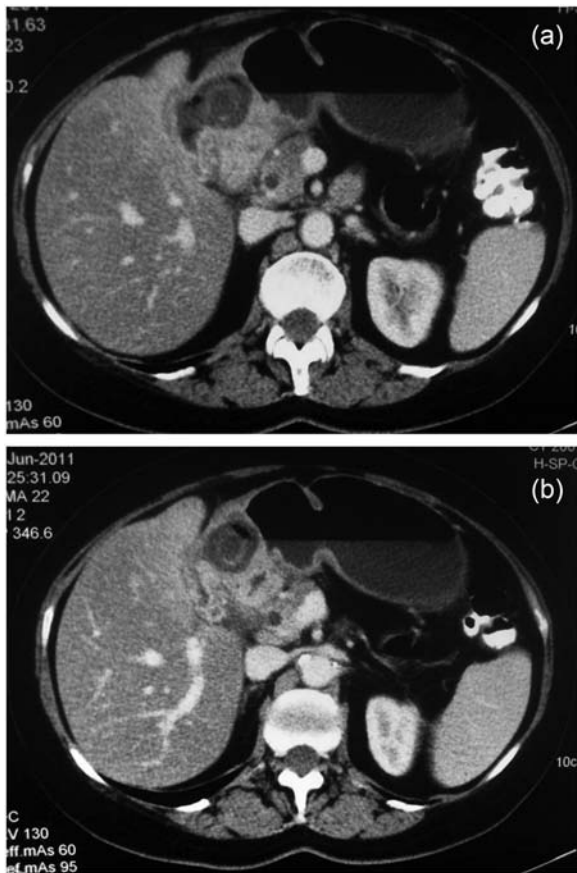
(a and b) CT of the abdomen.
